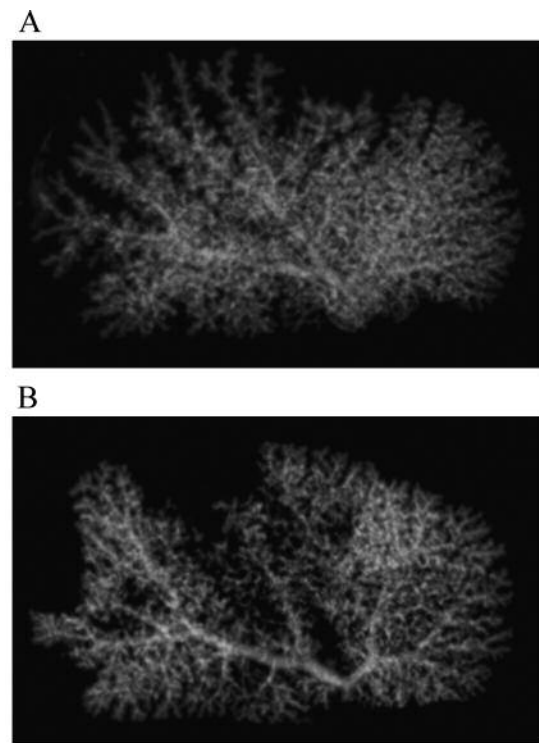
Blood vessel damage caused by soybean oil. Soybean oil (A: 0.05 ml, B: 0.1 ml) was administered into the portal vein. Two days later, 0.2 ml of barium sulfate was administered into the portal vein. X-ray computed tomography imaging of the liver leaf was performed.
